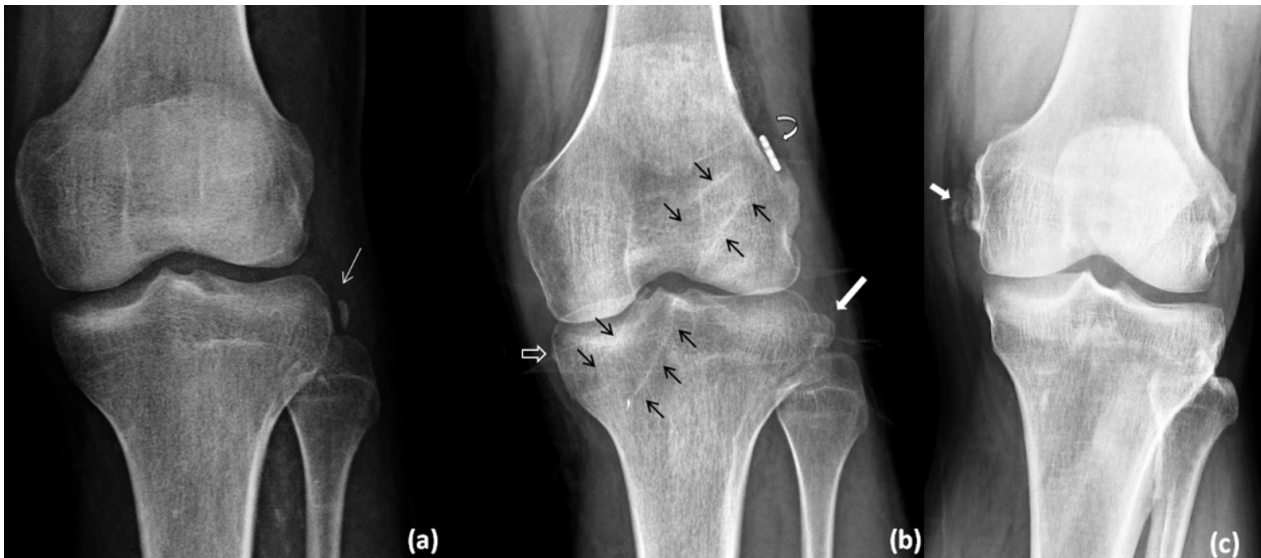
Anteroposterior knee radiograph of a 19-year-old male patient at his initial admission (a) after a knee injury during skiing shows the Segond fracture (arrow in a). Postoperative control radiograph at 8th month (b) after anterior cruciate ligament (ACL) reconstruction surgery demonstrates a bony bump on the lateral aspect of proximal tibia representing a healed Segond fracture (thick arrow in b). The tibial and femoral tunnels (black arrows) and endobutton (curved arrow) which is used to anchor the reconstructed ACL graft are clues to the patient's prior trauma and ACL reconstruction surgery. Note that, although the initial radiograph does not depict an avulsed fragment on the medial side of the proximal tibia, a slight bony irregularity has developed at the typical location of a reverse Segond fracture in the follow up radiograph (open arrow in b). The patient has sustained injury of the deep medial collateral ligament at its tibial attachment site (not shown here). In the anteroposterior knee radiograph of another patient with a history of knee injury 4 weeks ago (c) the Pellegrini- Stieda lesion is appreciated (arrow in c).
